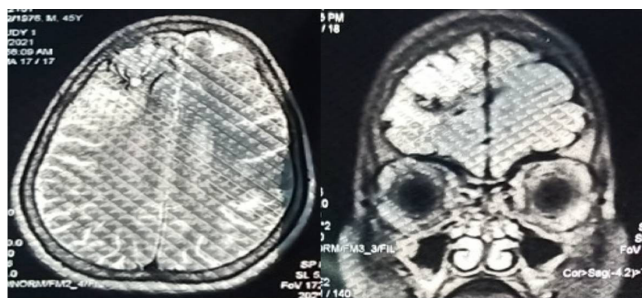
MRI brain showing lesion in right frontal lobe.
